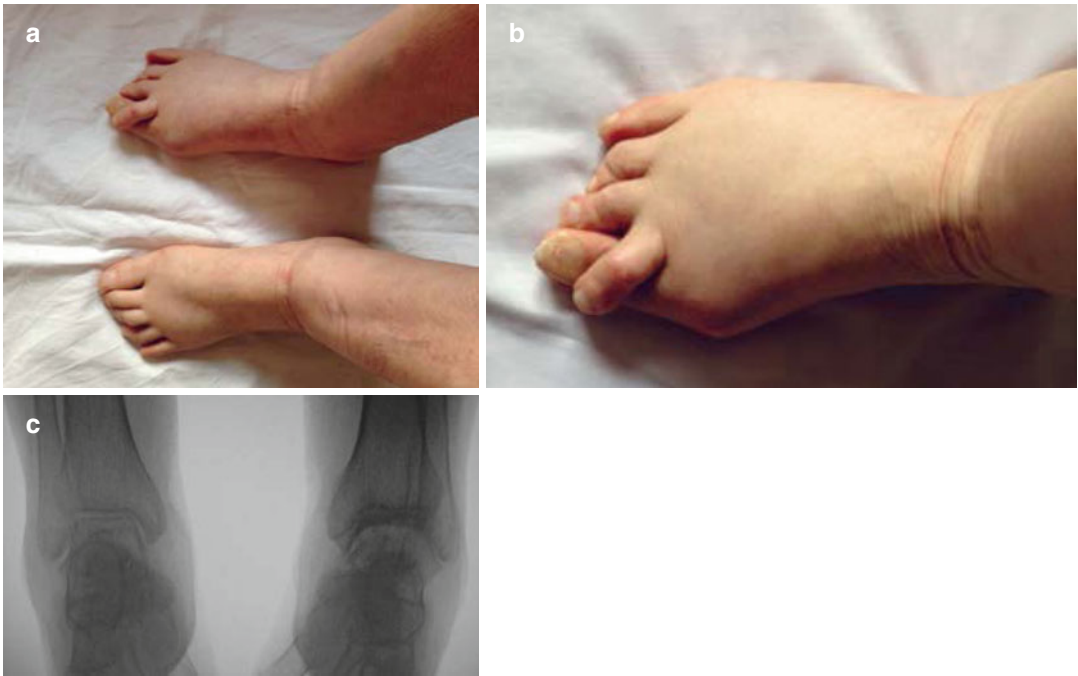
(a–c) RA patient presenting hallux valgus deformity (a), cock-up deformity that is the result of overriding of the second finger by MTP joint extension, adduction, and lateral rotation on the first finger (b). Joint erosion of a patient with the tibiotalar joint involvement on the AP X-ray of the ankle (c)
